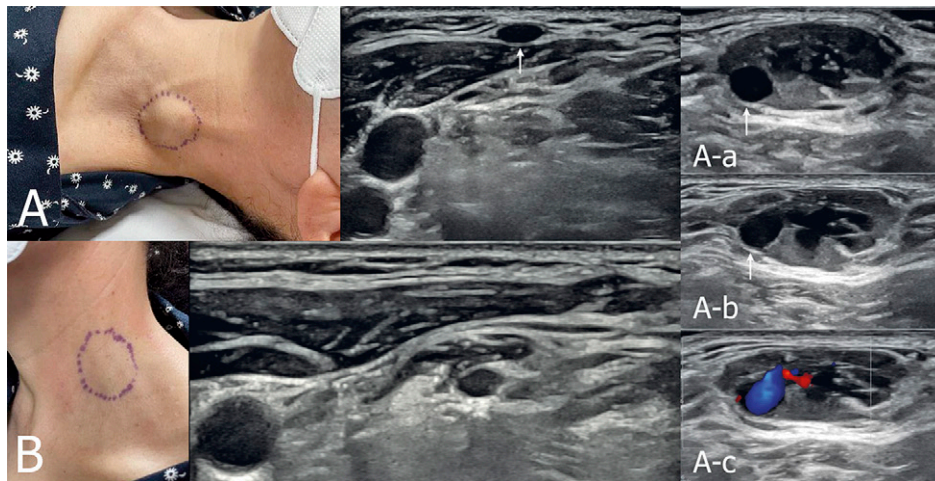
Ultrasound images of the venous malformation: (A) In the supine position, the lesion is visible with multiple cystic components; (B) In the erect position, the lesion disappears, demonstrating resolution due to positional changes. The arrows indicate the external jugular vein.
